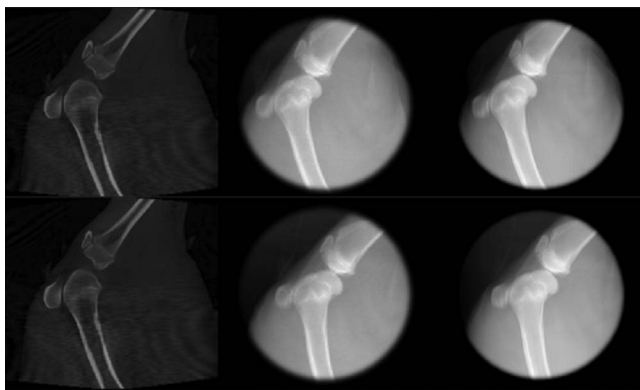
Data used for experiments (B). Left column: Coronal slices of the 3D-RX data sets. Center column: Anterior-posterior x-ray images that were masked using a Gaussian binary blurred disk. Right column: Anterior-posterior orthogonal projection images obtained with the projection-slice theorem. X-ray and projection images correspond to the 3D-RX data set in the same row.
